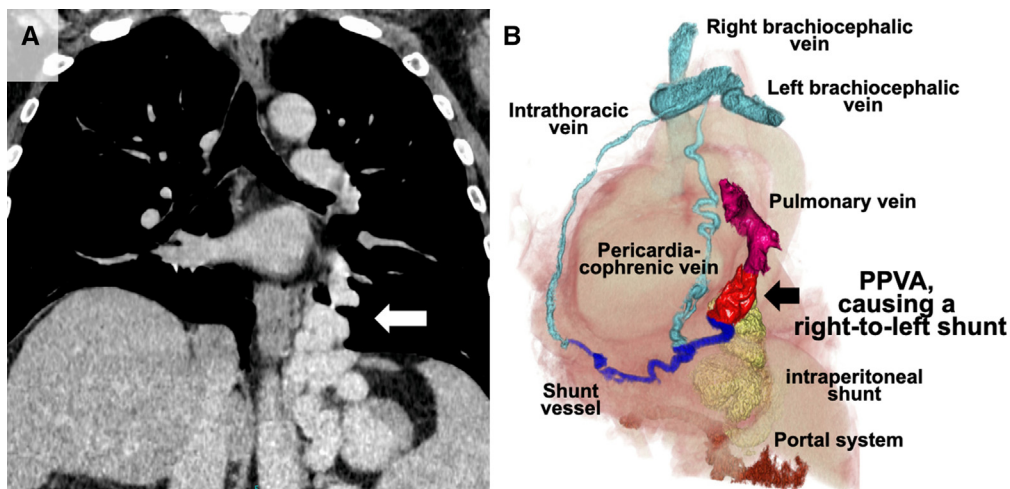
Enhanced chest computed tomography. A, Preoperative image shows a portopulmonary venous anastomosis, which flows from the left inferior diaphragmatic vein to the left inferior pulmonary vein (*white arrow*). B, The left lateral view of the 3-dimensional image. The *yellow* vessel demonstrates an intraperitoneal shunt from the portal system (*brown*). The portopulmonary venous anastomosis (*red*) flows into the inferior pulmonary vein (*pink*), causing a *right-to-left* shunt. The shunt vessel on the diaphragm (*blue*) flows into a pericardiacophrenic and intrathoracic vein, reaching the right atrium through the left brachiocephalic vein and superior vena cava (*light blue*).
